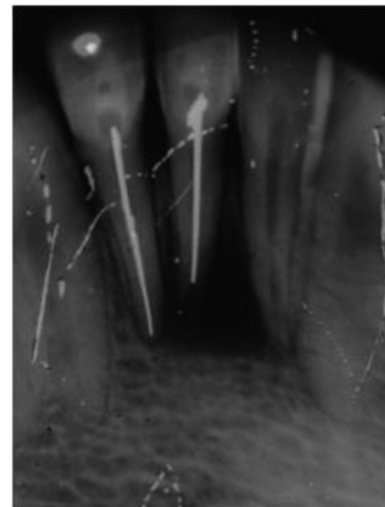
Pre-operative Radiograph wrt 31,32,41 showing large periapical lesion and silver point obturation wrt 31, 32.
